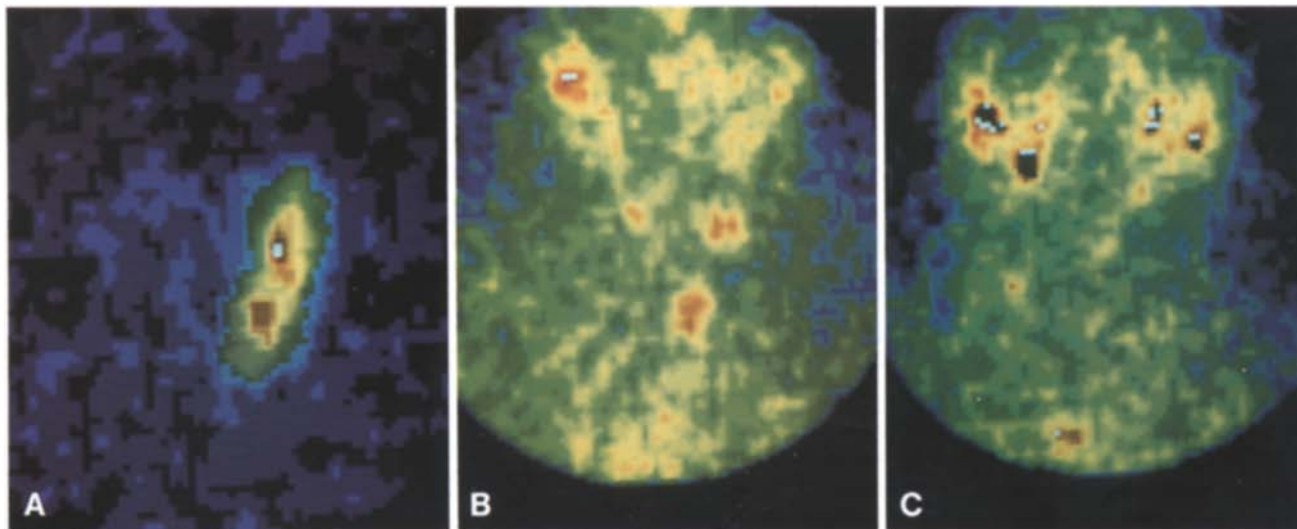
A 36-year-old man with medullary thyroid carcinoma (number 2, Table 6). A Following right hemithyroidectomy, the ^{131}I -MIBG scintigraphy imaged the tumor involved residual lobe. The tumoral involvement was subsequently confirmed by surgery (free radioiodine uptake was blocked by administration of triiodothyronine and Lugol's solution). B Multiple foci of abnormal uptake corresponding to the residual tumor were detected in the neck after total thyroidectomy. C Partial regression of the residual disease demonstrated by scintigraphy after administration of a total dose of 15.9 GBq (430 mCi) ^{131}I -MIBG
